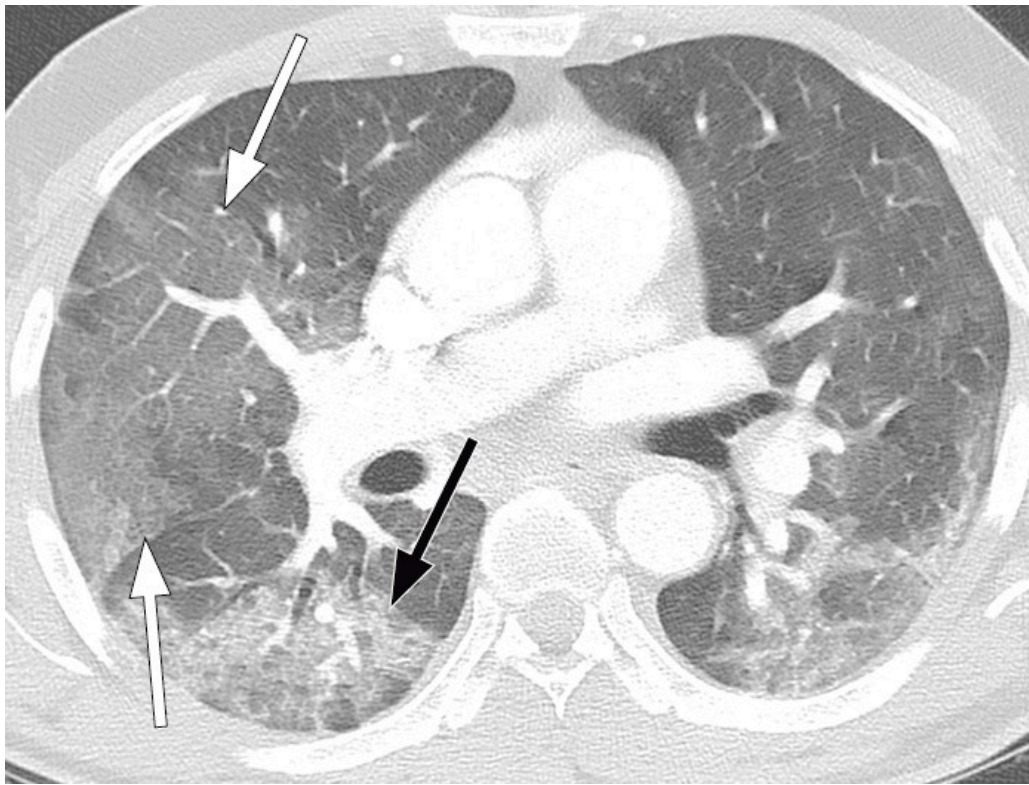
Patient with COVID-19. Chest CT seven days after symptom onset shows extensive bilateral ground-glass opacities (white arrows), only limited consolidation (black arrow).
